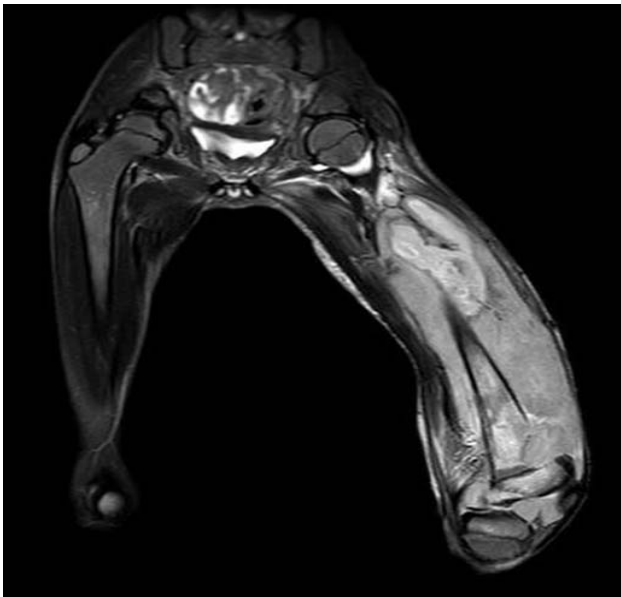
T2w MRI with IV contrast image showing a large soft tissue mass involving the left thigh which is extending to the knee joint with intraosseous extension into distal femoral diaphysis together with marrow edema.
